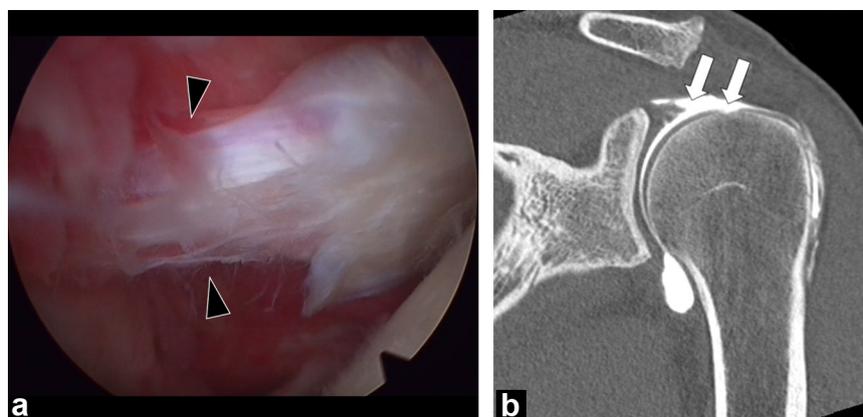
A and B) Arthroscopic view of a LHB tendon in a 47 year-old man with no clinical signs of biceps tendon pathology . LHB tendon appears continuous, with a regular caliber (star) and discrete zone of tendon hyperemia (arrowhead) C) CT arthrography image of the same patient in an oblique coronal plane showing the proximal LHB tendon with regular contours and uniform thickness .
